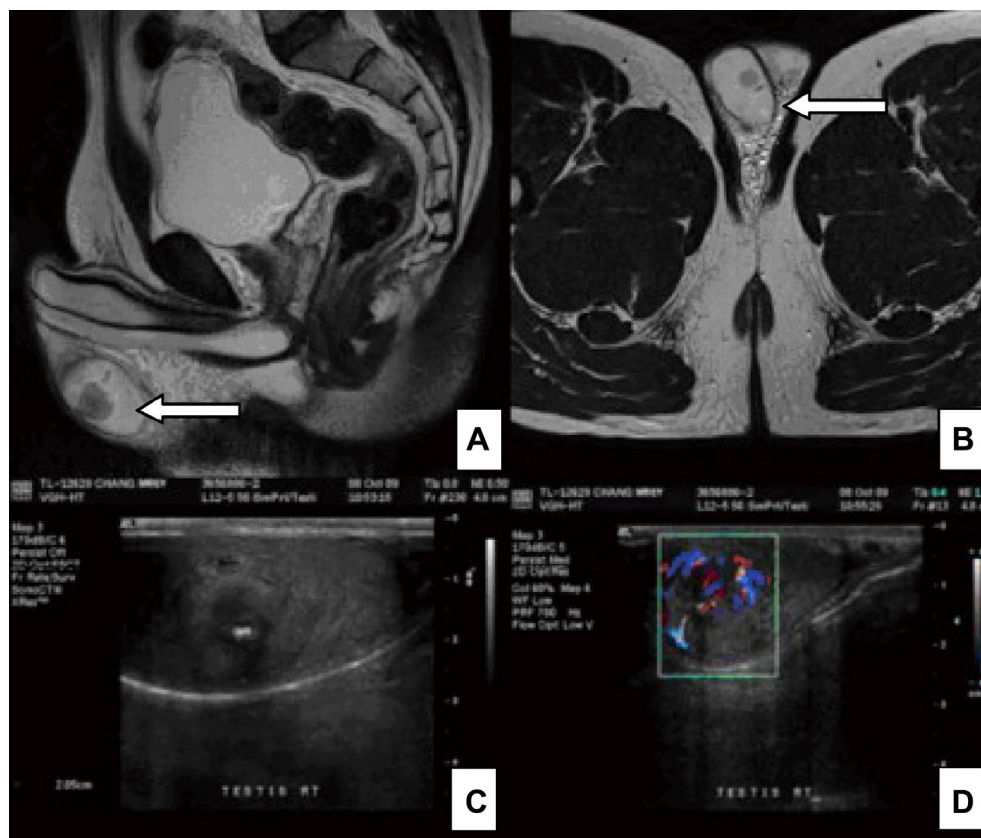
(A and B) Preoperative magnetic resonance image showed a T2 hypointense nodule about 2 cm in size, with coarse calcification being noted in the right testis (arrow). (C and D) Scrotal sonogram showed a heterogeneous echogenic nodule 2 cm in size in the right testis with central calcification and increased vascularity.
